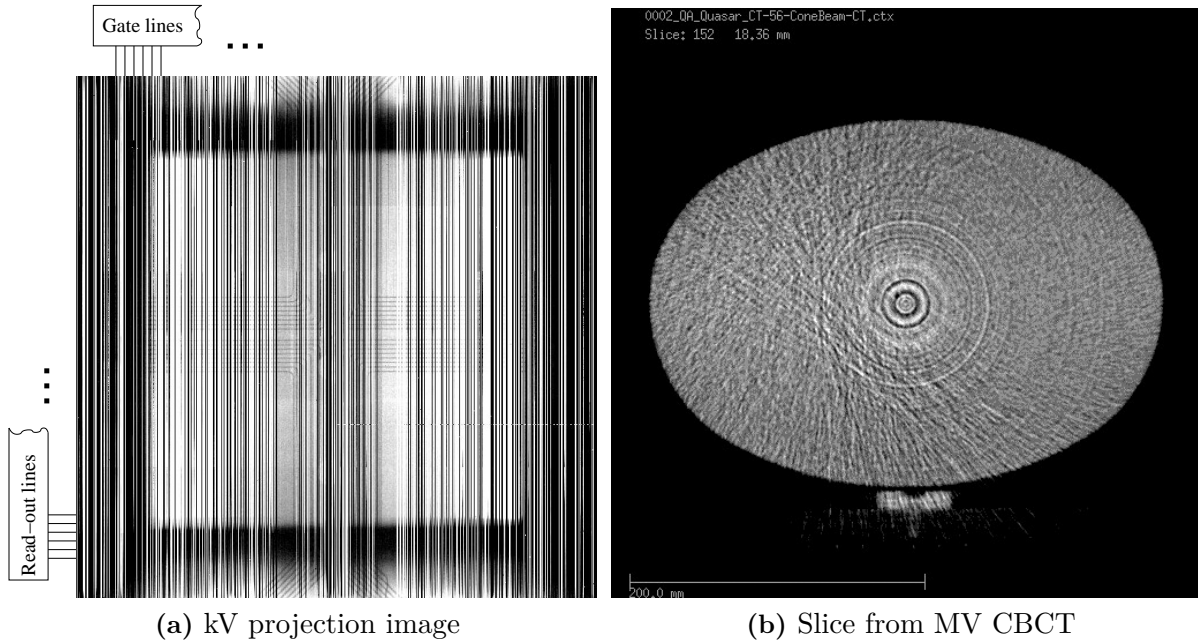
Examples of artifacts encountered in x-ray images acquired during asynchronous, concurrent EM tracking.*
